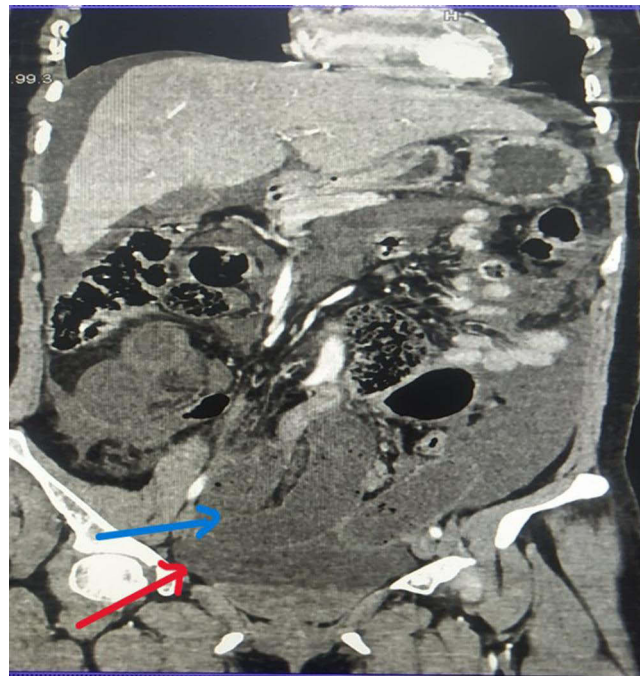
Sagittal CT abdomen demonstrating dilated bowel loops (blue arrow) and ascites (red arrow).
